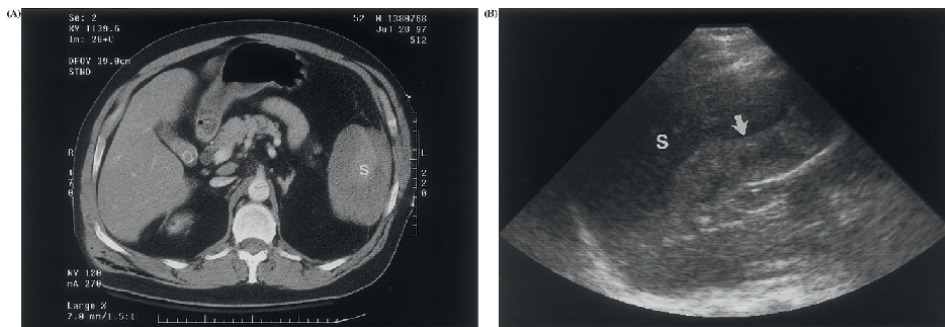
Spleen injury of subcapsular hematoma as seen on CT (left) and USG (right) [13].
